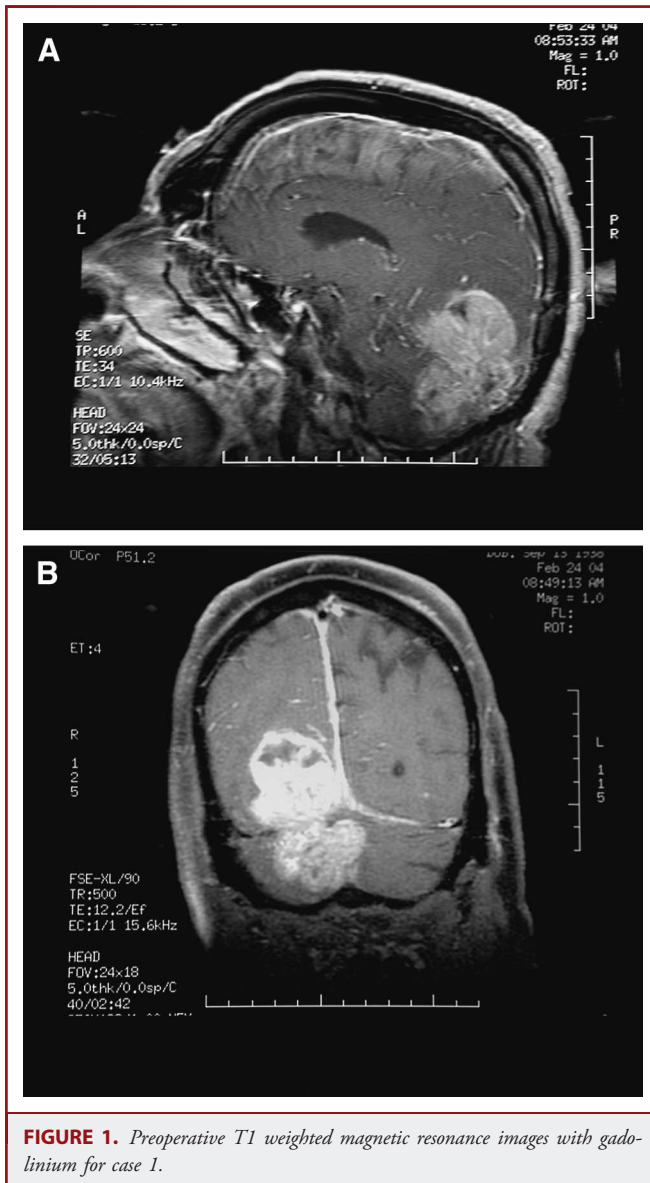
Preoperative T1 weighted magnetic resonance images with gadolinium for case 1.
